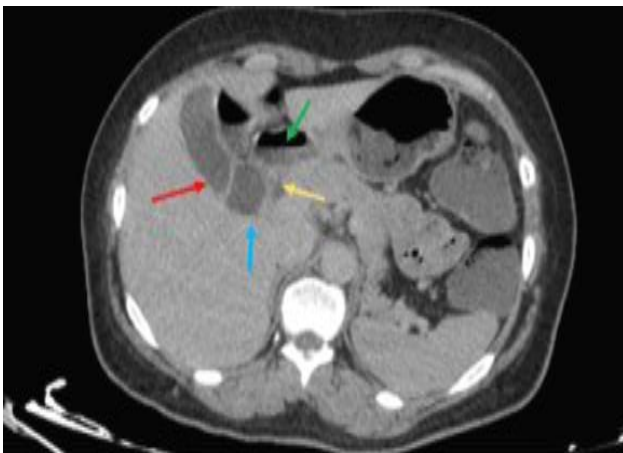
CECT abdomen image of axial plain CT.
